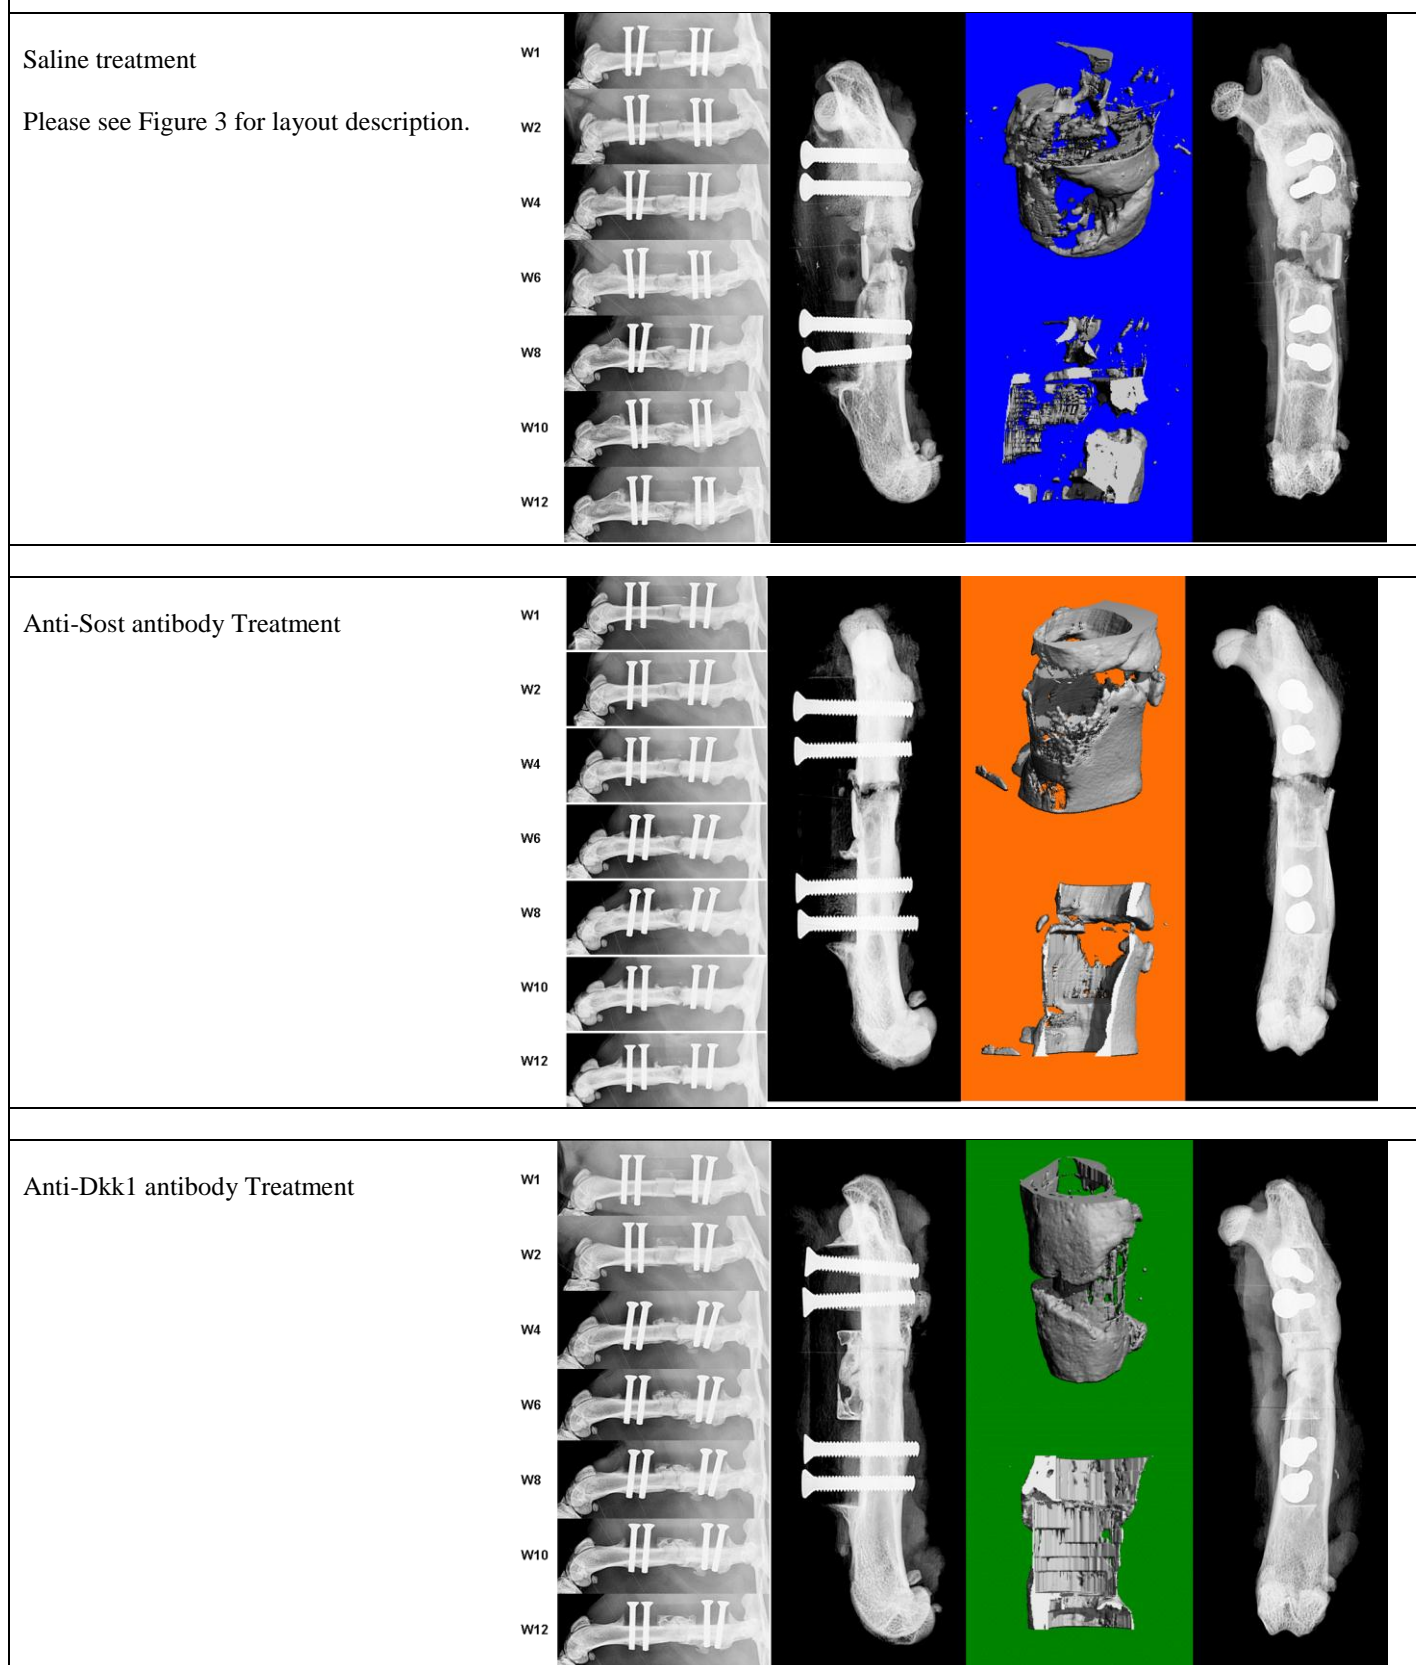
In vivo radiographs, ex vivo radiographs and μ CT scans for 12 week time point
